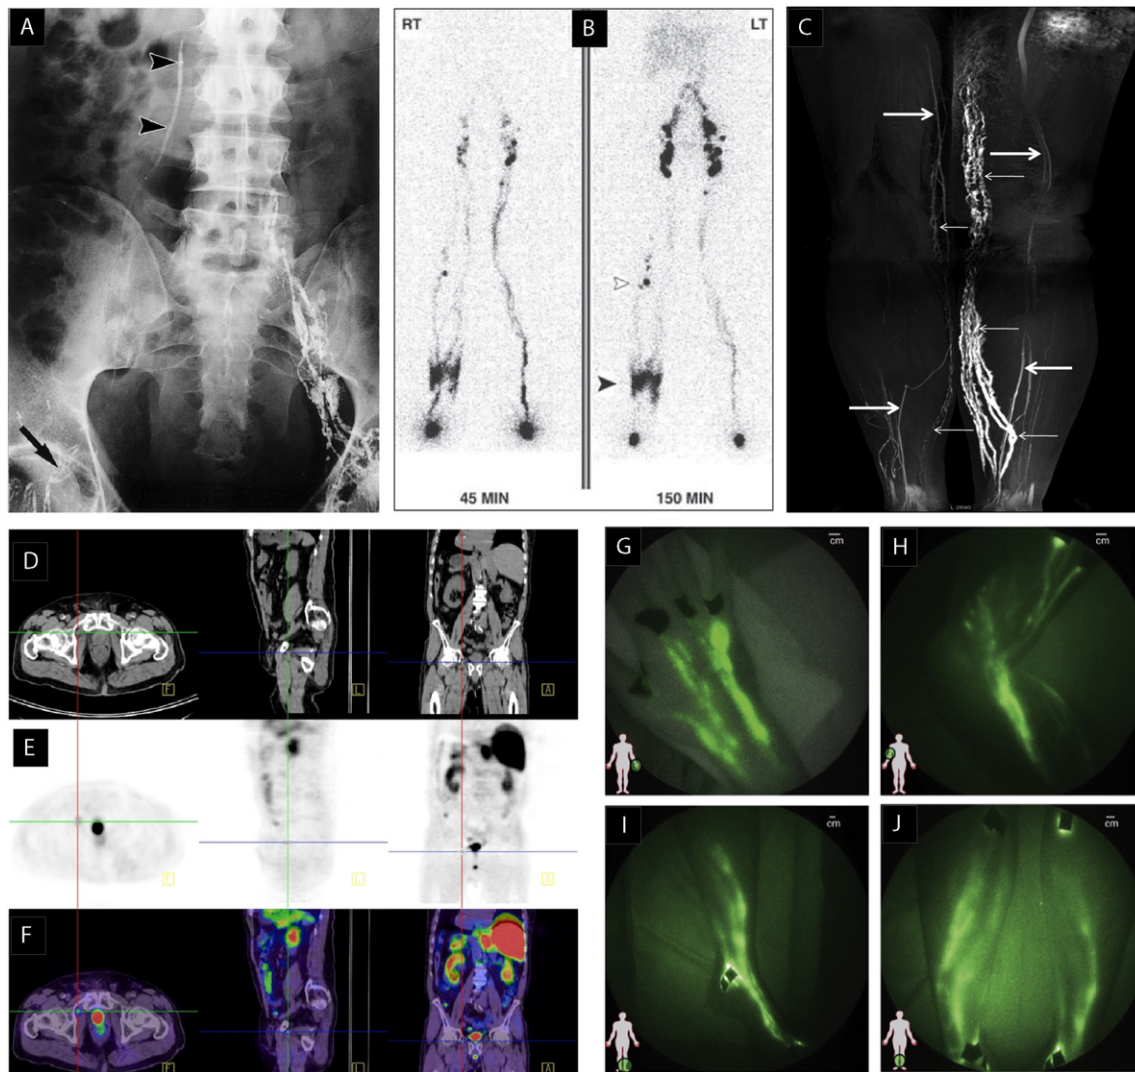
Imaging lymphatic vessels and lymph nodes in the clinic. (A) Lymphogram of a patient with lymphovenous shunt after surgery for right-sided inguino-crural hernia showing lack of lymph flow in the inguino-crural region (arrowheads) (Guermazi et al., 2003, reproduced with permission). (B) Lymphoscintigraphy of bilateral limb swelling. Lymph rerouting through the skin of right lower limb (solid arrowhead) and the deep lymphatics is apparent. Several popliteal nodes (open arrowhead) are visible. The left limb appears normal in this lymphoscintigraph (Burnand et al., 2011, reproduced with permission). (C) Coronal 3D MR lymphography image of the lower extremities obtained after subcutaneous injection of contrast material. Abnormal, dilated lymphatic vessels extend from the left calf to the inner thigh (small arrows). Some lymphatic vessels in the contralateral normal limb appear discontinuous (small arrows). Veins appear as linear structures with lower intensity (large arrows) (Lu et al., 2012). (D–F) PET-CT after radical prostatectomy. CT images are in (D), PET images 60 min after the administration of ^{18}F -choline are in (E) and merged PET-CT images are in (F). The high intensity spot in the PET scan is a small right inguinal lymph node with likely metastasis (F: transverse plane; L: saggital plane; A: coronal plane) (Fortuin et al., 2013). (G–J) Near infrared imaging of healthy lymphatics in normal subjects. Lymphatic vessels in (G) hand, (H) arm, (I) foot, ankle, and leg, and (J) lower legs. Black spots are covered injection sites (Rasmussen et al., 2009, reproduced with permission).
